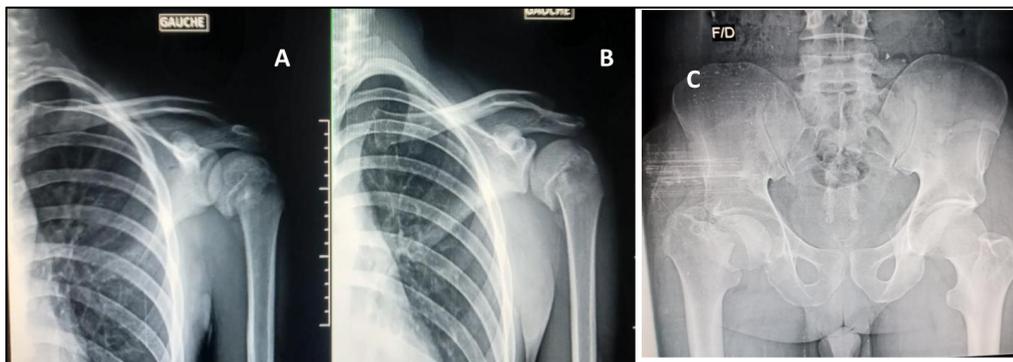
(A, B and C): X-ray of the left shoulder in AP and oblique incidence (A and B) of the pelvis from the AP (C) shows a dislocation fracture of the left humeral head (A and B) and a complex unstable overlapping fracture of the right femoral neck passing through the trochanters (C)
